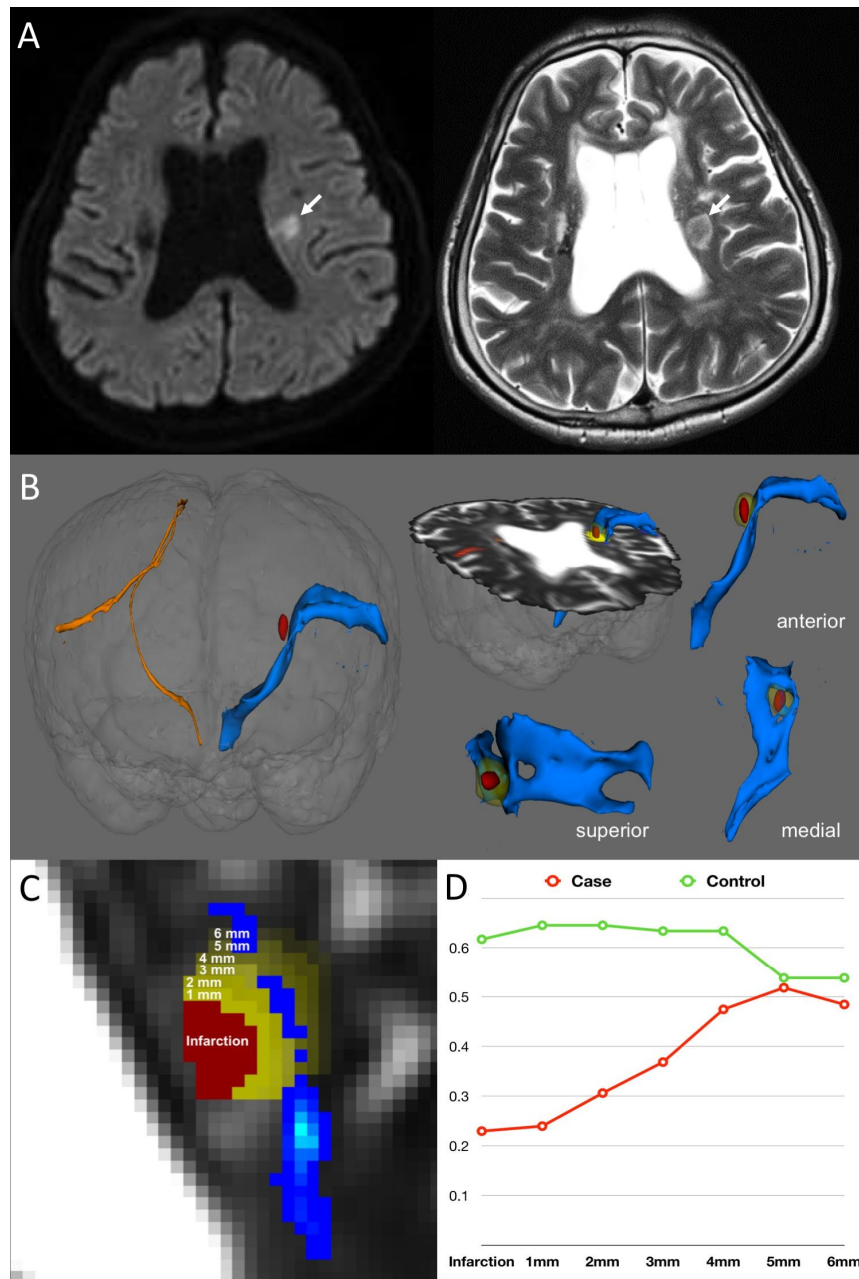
(A) Left periventricular white matter infarction on diffusion-weighted (onset) and T2-weighted image (3weeks later). (B) Diffusion tensor tractography (3weeks later). Focal degeneration of left corticobulbar tract (blue) adjacent to the infarction (red) and perilesional edema (transparent yellow). (C) Perilesional fractional anisotropy values decrease with the distance compared with 5 healthy controls.
